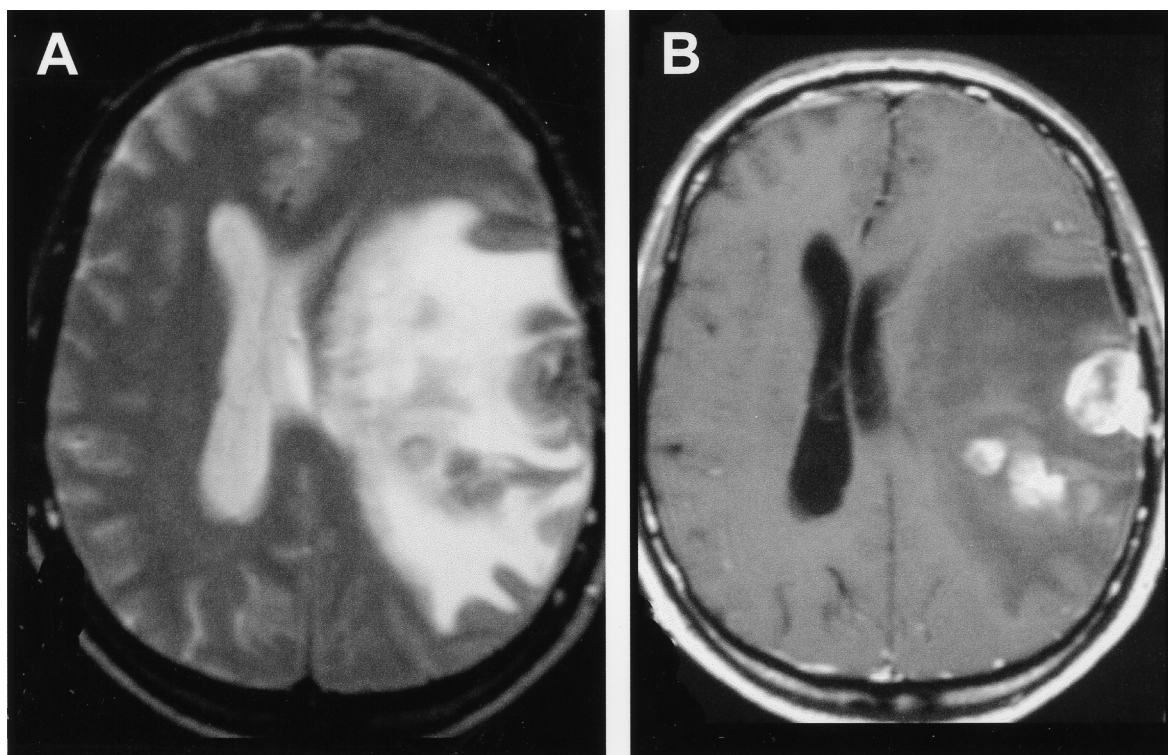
(A) MRI study. Axial spin-echo T2-weighted image (TR/TE 2200/75) demonstrates the presence of a fronto-temporal cortical–subcortical hypo-isointense lesion (arrow) with significant edema and a mass effect on median structures. (B) Contrast-enhanced spin-echo T1-weighted (TR/TE 500/15) axial image. Gadolinium injection better delineates the lesion, which enhances strongly, showing the presence of multiple nodules.
